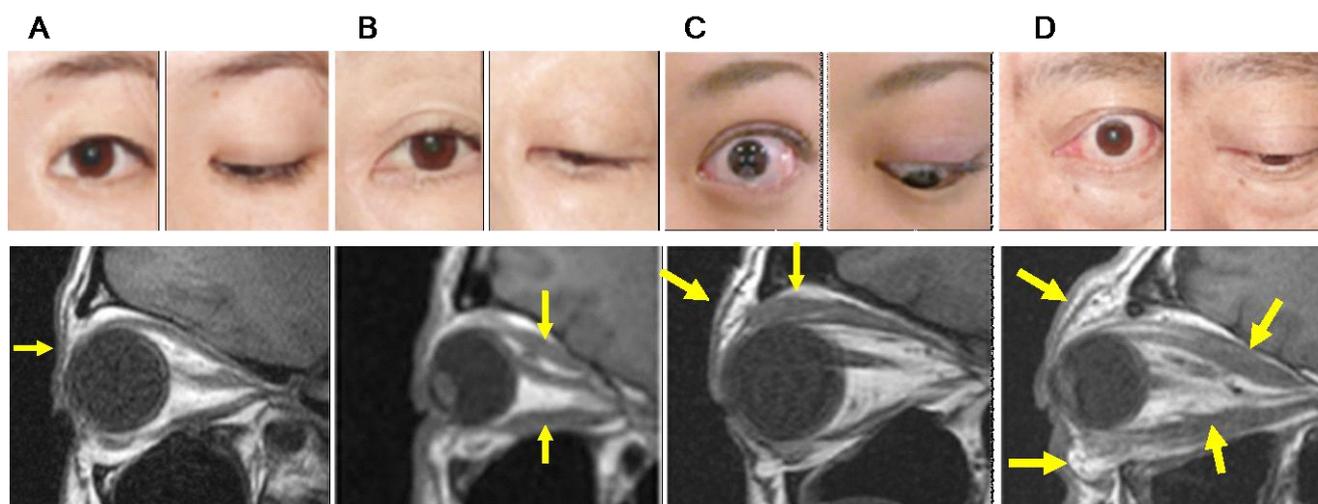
Orbital MRI (T1-weighted parasagittal sections) in 4 patients. A: Patient without signs, or symptoms; MRI indicates no enlargement of muscles; B: Patient without signs, or symptoms; MRI reveals the enlargement of superior and inferior rectus muscles; C: Patient with Dalrymple sign, von Graefe's sign and proptosis; MRI reveals the enlargement of levator palpebrae superioris muscle; D: Patient with Dalrymple sign; MRI shows the enlargement of superior and inferior rectus muscles. Arrows indicate the lesions. (modified from Hiromatsu Y, *Nippon Naika Gakkai Zasshi*. 2010; 99:755-62, 2010).
